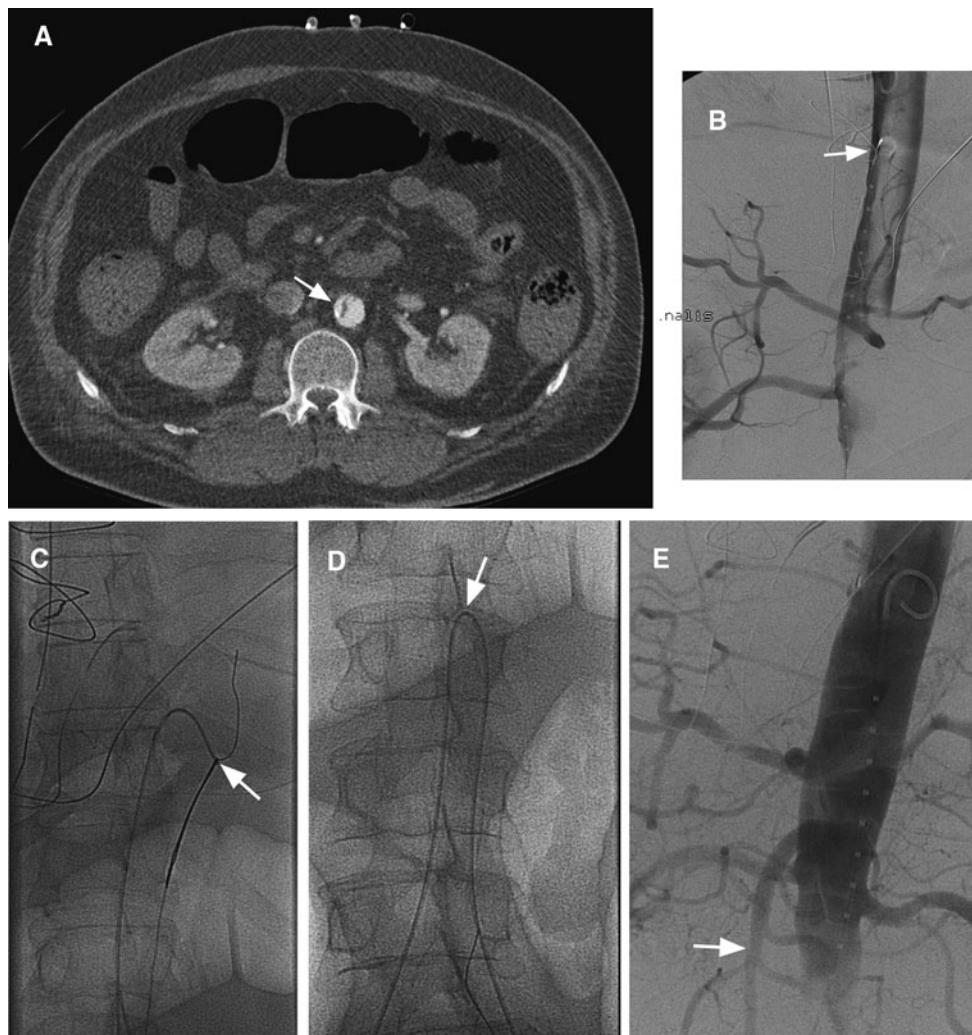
Seventy year old male patient 1 day after aorto-coronary bypass surgery with iatrogenic type A dissection necessitating operative hemi-arch reconstruction. Within the postoperative course, metabolic acidosis was noted and CTA (A) documented extension of the dissection into the abdominal aorta with severe compression of the true lumen (arrow in A). This was confirmed by flush angiography
